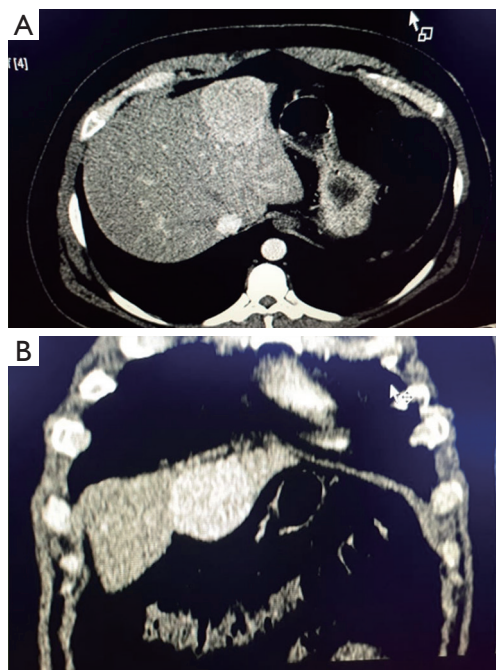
CT-scan. (A) Cross section study showing a solid nodular lesion in segment IV of the liver with enhancement to the intravenous contrast medium and measurements in an axial contour of 51×47 mm². (B) Coronal section of the lesion where no pulmonary infiltrates are identified.
